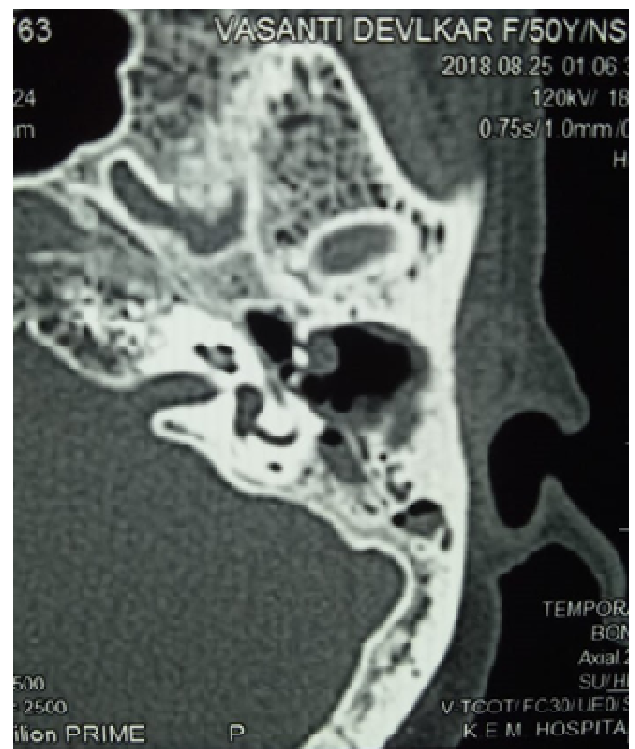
a & b. High resolution computed tomography scan showed soft tissue density involving left external auditory canal, middle ear and mastoid air cells with erosion of poster inferior canal wall, facial canal
